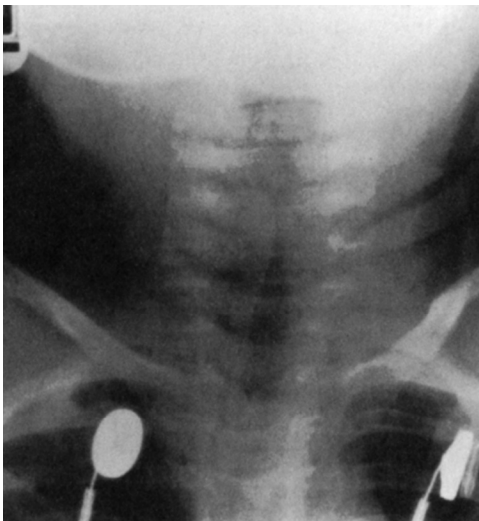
Laryngotracheobronchitis. The anteroposterior neck radiograph reveals steeply angled subglottic walls (“steep sign”).
